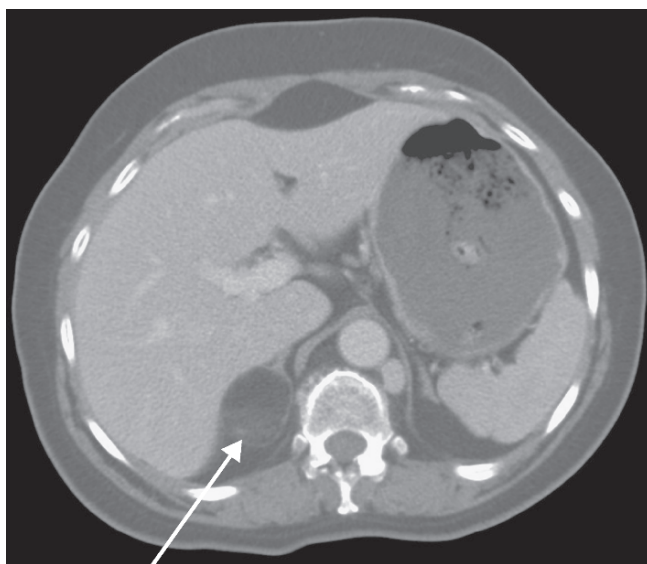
Adrenal myelolipoma. Contrast-enhanced CT scan showing fat containing mass in right adrenal (arrow) consistent with a myelolipoma
